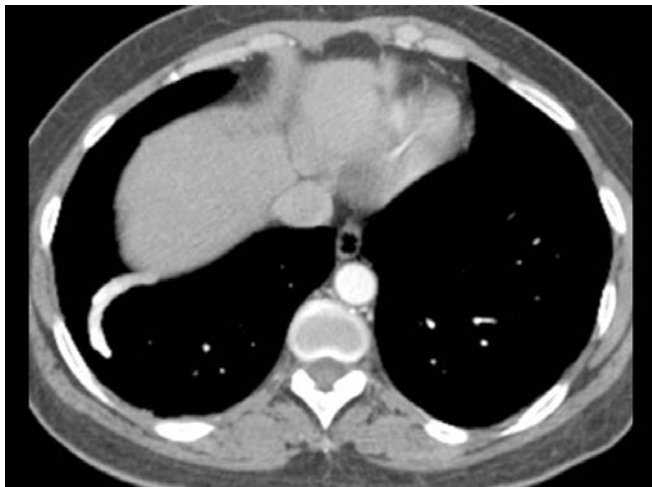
CT chest with contrast showing a dilatation of the pulmonary vein from a pulmonary varix
